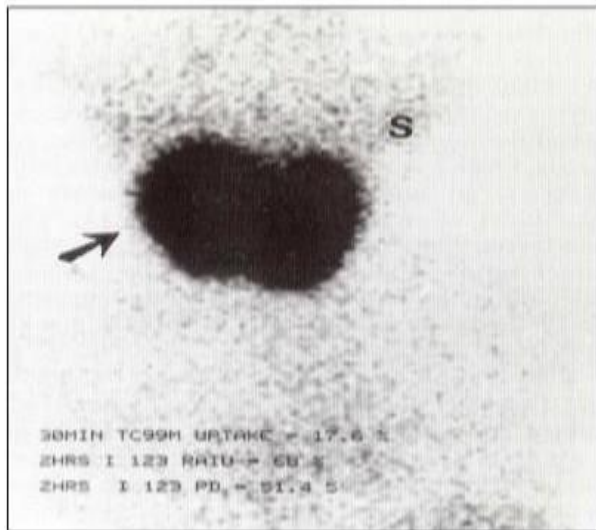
99mTc-pertechnetate thyroid scintigraphy revealing an eutopic enlarged gland (arrow), which is demonstrating a marked increase in activity. S, salivary gland
